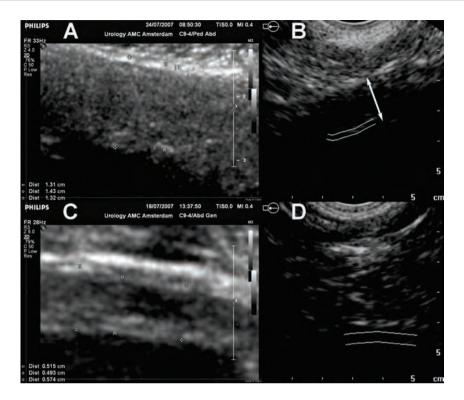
Bladder wall thickness measurements of a patient with conventional ultrasound (A) in comparison to the corresponding image of the BVM 6500 device (B). Note that the enlargement factor of figure 4A is half compared to figure 1. The patient had a thick bladder wall due to urodynamically confirmed severe bladder outlet obstruction (patient 17, first measurement at 250 ml). Bladder wall thickness measured with conventional ultrasound was greater in comparison to the measurement with the BVM 6500 device which measured only the inner part of the anterior bladder wall (\approx). The double arrow (1) in figure 4B indicates the true bladder wall thickness which is comparable with the measurement value of conventional ultrasound.
